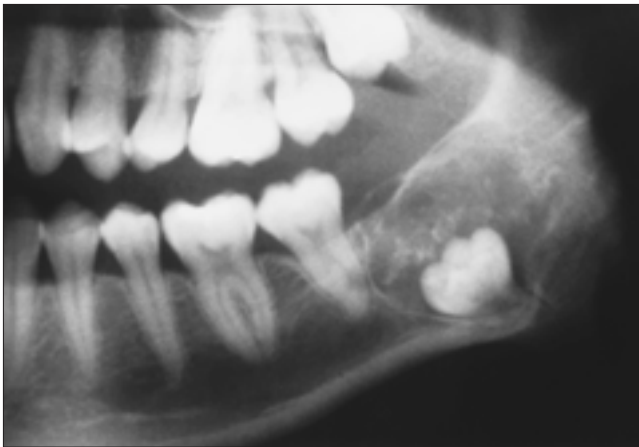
Panoramic radiograph showing a mixed radiolucent-radiopaque lesion in the left angle of the mandible.
